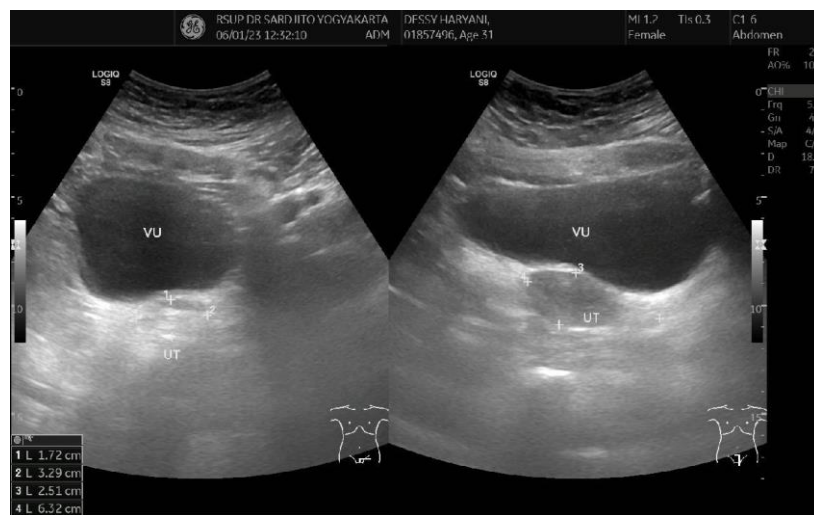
Ultrasound examination of the lower abdomen
